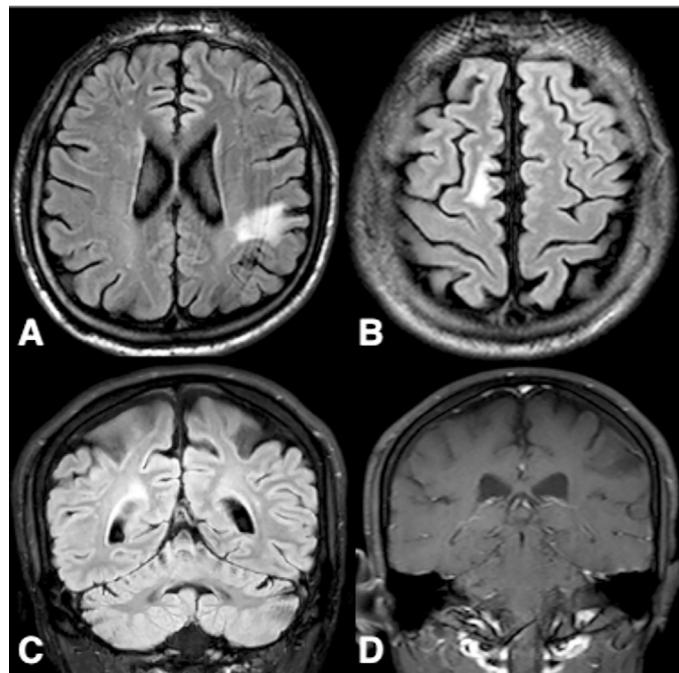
Brain MRI (A,B). Axial T2-FLAIR demonstrate hyperintense lesions in the left frontoparietal cortical/juxtacortical region (A) and the right posterior frontal cortical/juxtacortical region (B). (C) Coronal T2-FLAIR image demonstrates a right periventricular hyperintensity. (D) Coronal postcontrast T1-weighted image demonstrates T1 hypointensity without gadolinium enhancement in the left frontoparietal lesion
